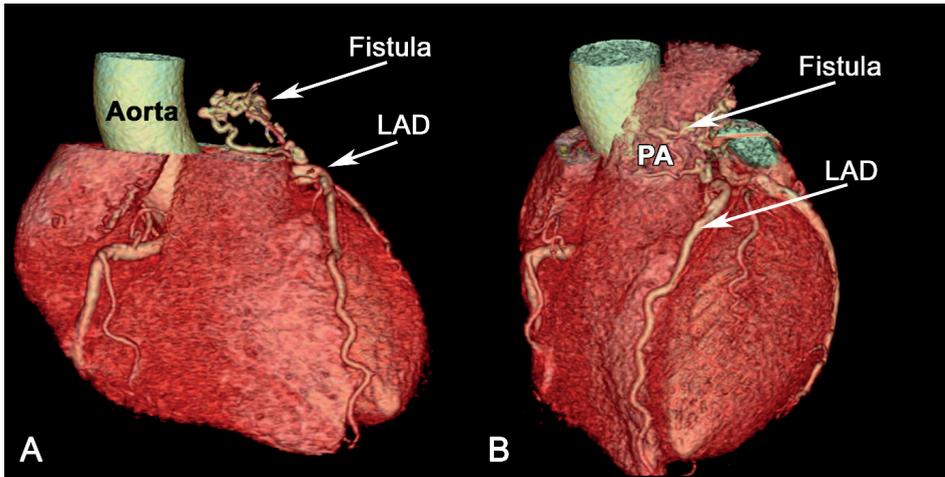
CCTA reveals a fistula from the left anterior descending artery (LAD) to the pulmonary artery (PA). CCTA = Coronary computed tomography angiography;
